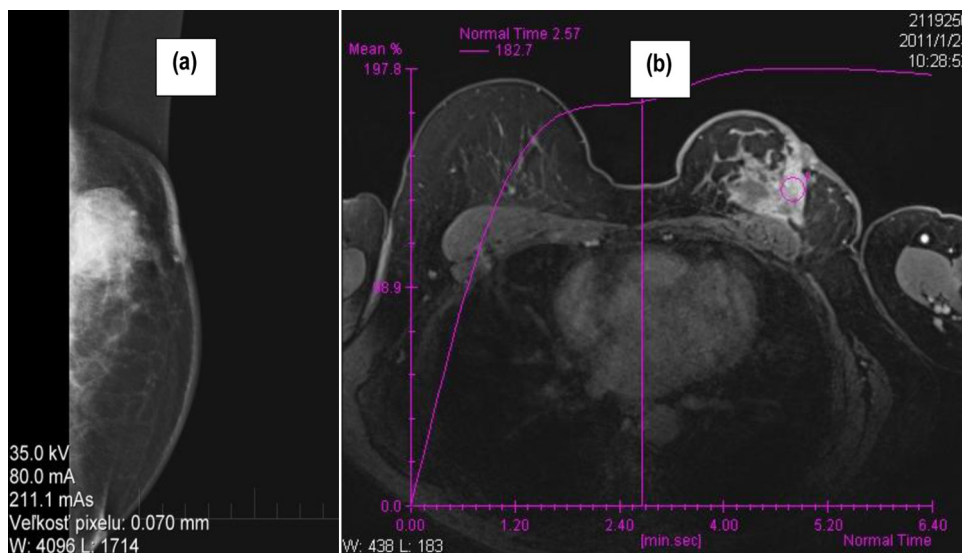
Patient 1 (a) mammography of the left breast – MLO projection – increased density of fibroglandular tissue with focal appearance in the upper quadrant of the left breast, (b) MRI of the breast-dynamic contrast enhanced study – markedly enhanced infiltration with retractive changes and middle to high proliferating activity.
